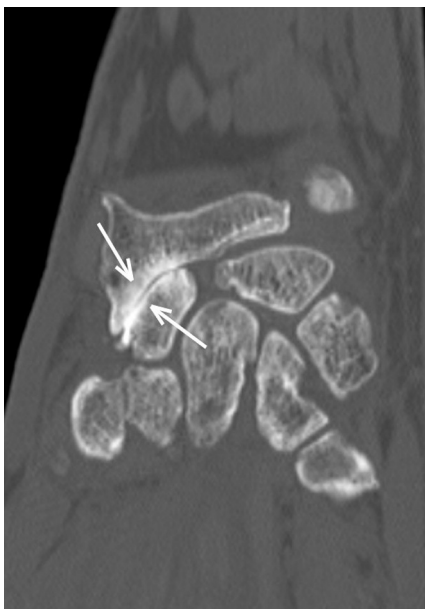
Coronal CT slice of the right wrist: pathological scapholunate diastasis, severe right radioscaphoid narrowing with subchondral osteosclerosis (arrows), fine calcifications in the scapholunate space and opposite the head of the capitate bone.
